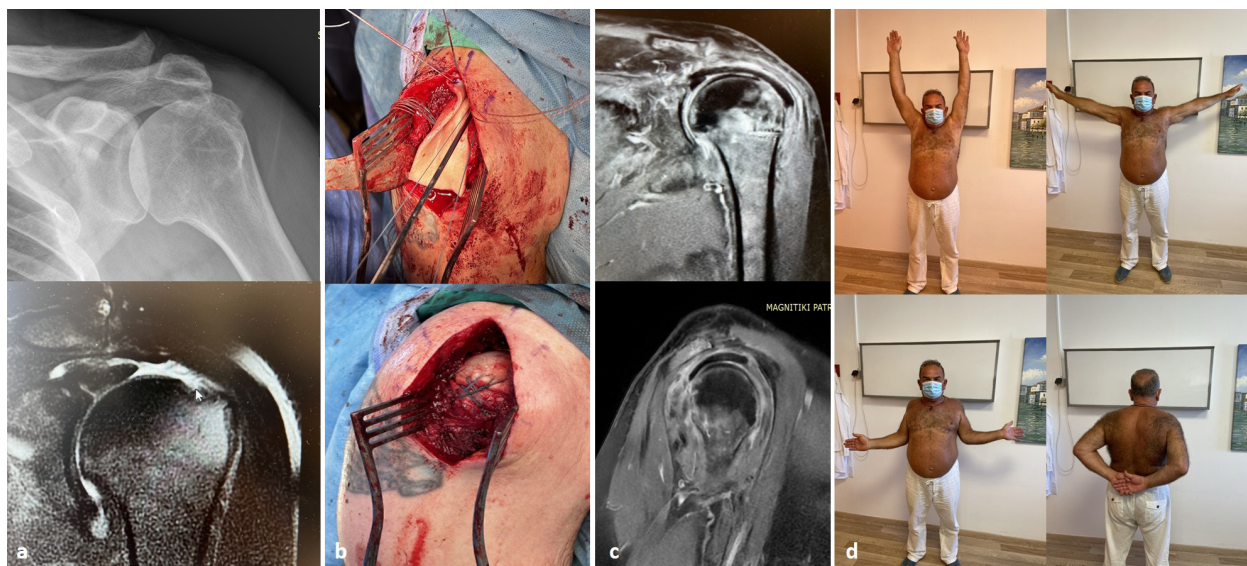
a) Preoperative x-ray (with no arthritis) and MRI (showing MIRCT) in a 57-year-old patient with pseudoparalysis, b) intraoperative photos showing the fixation of the dermal allograft in the glenoid and the final suture bridge configuration; site to site repair has also been accomplished with the remain tendons, c) 1-year follow-up MRI showing maintenance of the allograft and suppression of the humeral head and d) the final clinical outcome at one year (Constant score 84).
